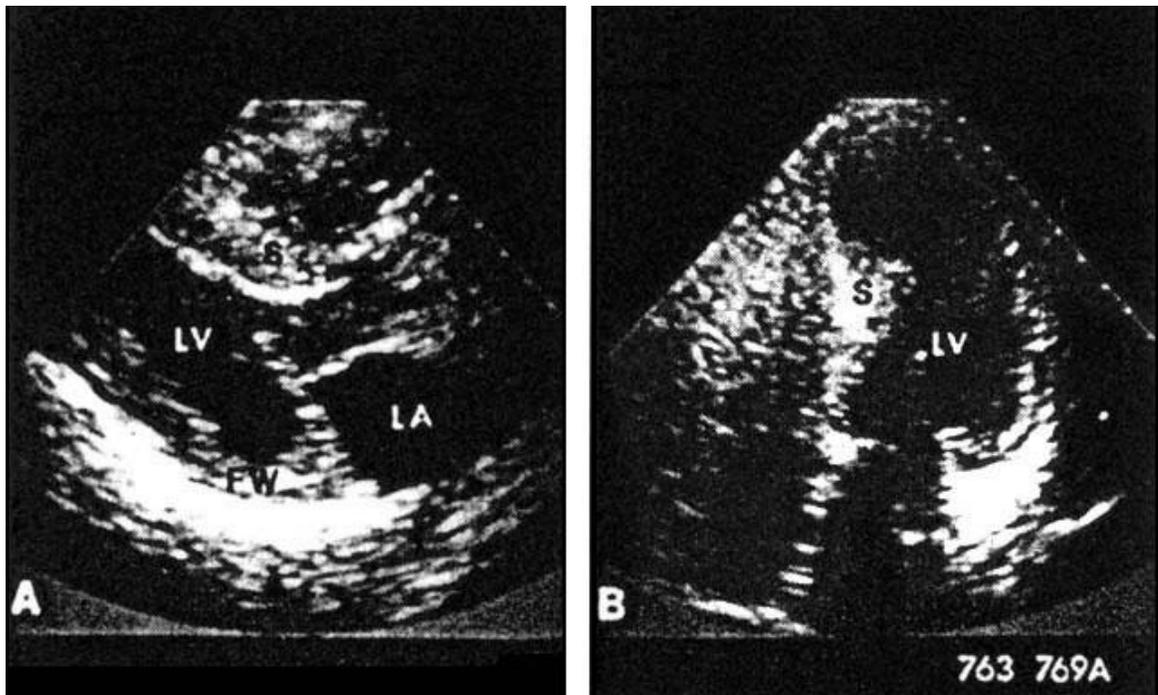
Doppler imaging of patient with Hypertrophic Cardiomyopathy. In image A, SAM can be indicated by the abnormal mitral valve moving towards the septum (labeled S above LV). Septal wall thickness can also be seen in Image B. Colored Doppler imagery may reveal systolic gradients used to help diagnose HCM (Shah, 2012).
